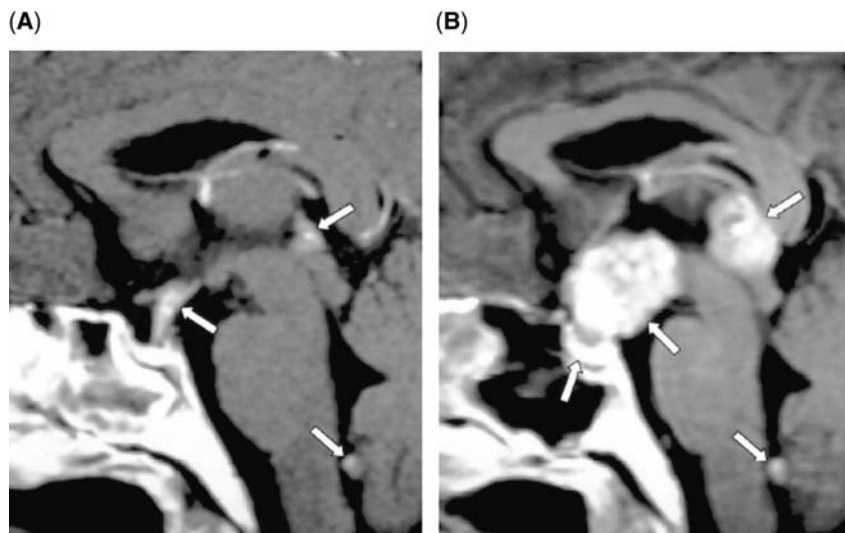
Magnetic resonance (MR) images of the pituitary stalk with a germinoma. (A) Initial contrast-enhanced sagittal T1-weighted MR image depicts mild thickening and homogeneous enhancement of the pituitary stalk. In addition, small nodular enhancing lesions are seen in the pineal gland and outlet of the fourth ventricle (arrows). (B) Contrast-enhanced sagittal T1-weighted MR image obtained one year later without treatment shows a marked increase in the size and inhomogeneous enhancement of those lesions and also of the pituitary gland (arrows). The focal enhancing lesion seen within the fourth ventricle appears to be cerebrospinal seeding. Germinoma was pathologically proven. Source: From Ref. 157.
